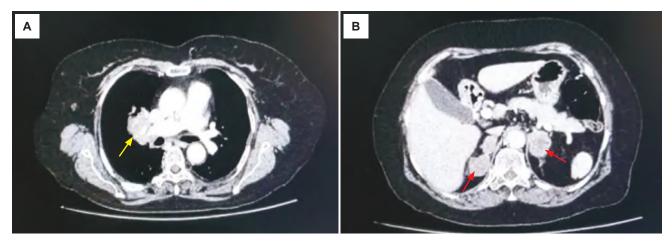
Computed tomography scan with contrast on axial view of the (A) thorax and (B) abdomen revealing a lobulated lesion at right perihilar area encasing the right pulmonary veins (*yellow arrow*), bilateral adrenal masses (*red arrows*) and bilobed right adrenal mass.
